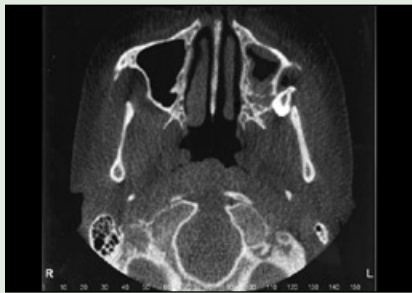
Axial computed tomography image shows the position of the displaced tooth 28 seen in Fig. 3 (imaging courtesy of Dr. Elaine Orpe).
